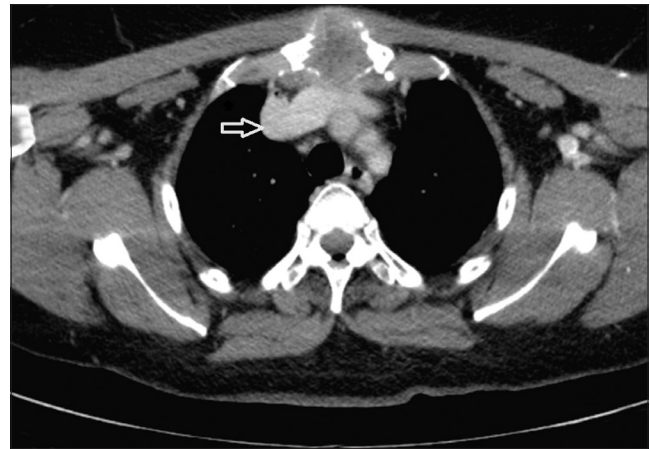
CT image showing extensive destruction of the manubrium
